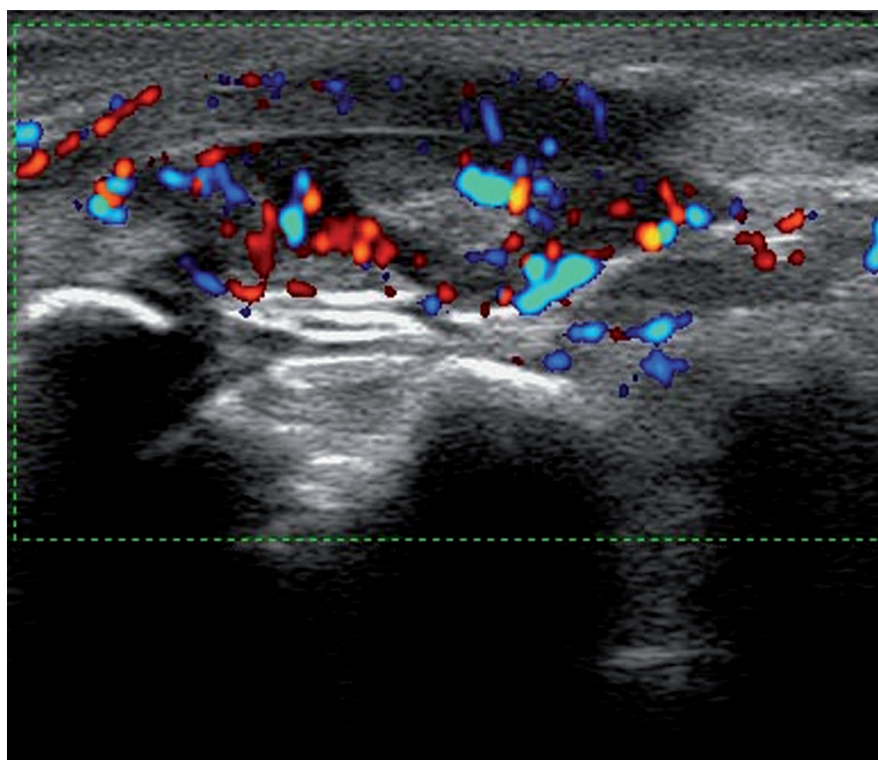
Transverse ultrasound image of the tibialis posterior tendon that shows tenosynovitis on B-mode and power Doppler mode (diffuse Doppler signal within the distended synovial sheath).
